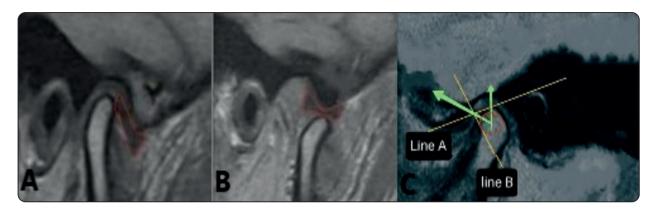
MRI image of the joint reveals disc displacement with reduction (A) Anterior disc displacement on mouth closure, (B) The disc is reduced to the normal positionon mouth opening, (C) In closed mouth position: Line A: From the superior margin of external auditory meatus to the articular eminence crest, line B: Posterior edge of the articular disc. The angle of disc displacement was measured between a line passing through the intersection of lines 'A' and 'B' and a line that corresponds to long axis of the condylar head ^[26].
